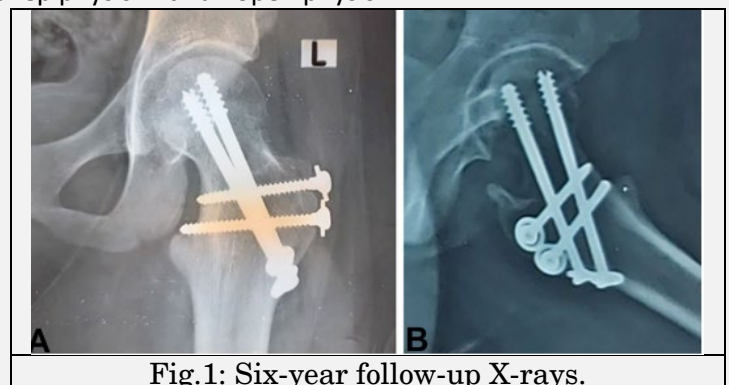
Six-year follow-up X-rays.
